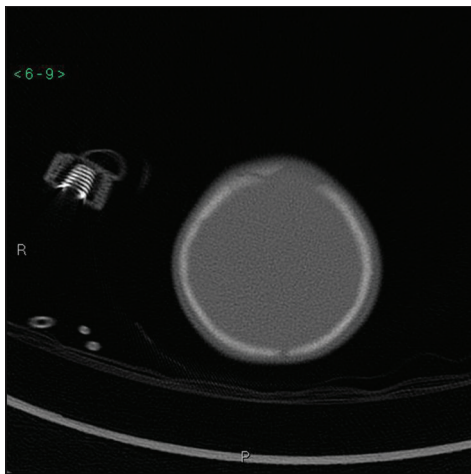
Noncontrast enhanced head CT
